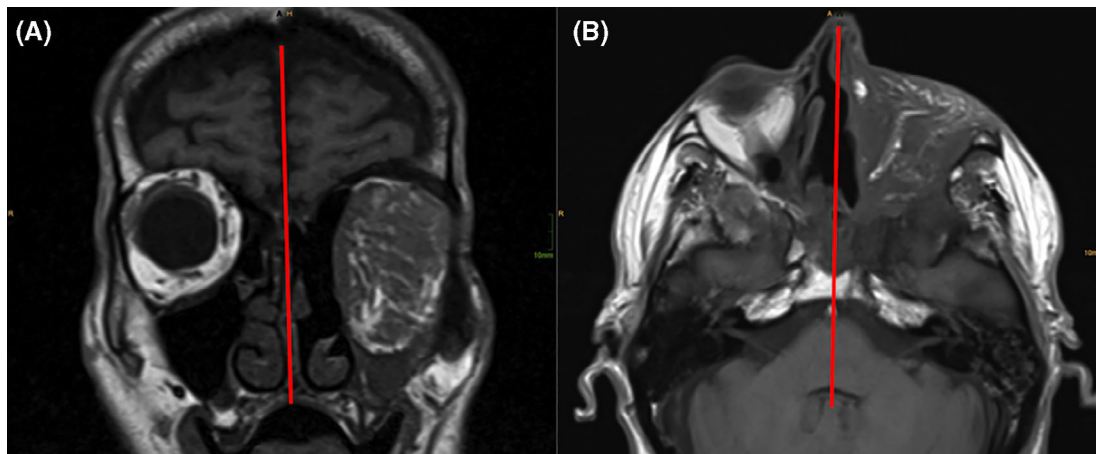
T1-weighted images of two patients in coronal (A) and axial (B) orientation. The minimum distance between the midline and the far medial border of the transferred tissue was measured [Color figure can be viewed at wileyonlinelibrary.com]
